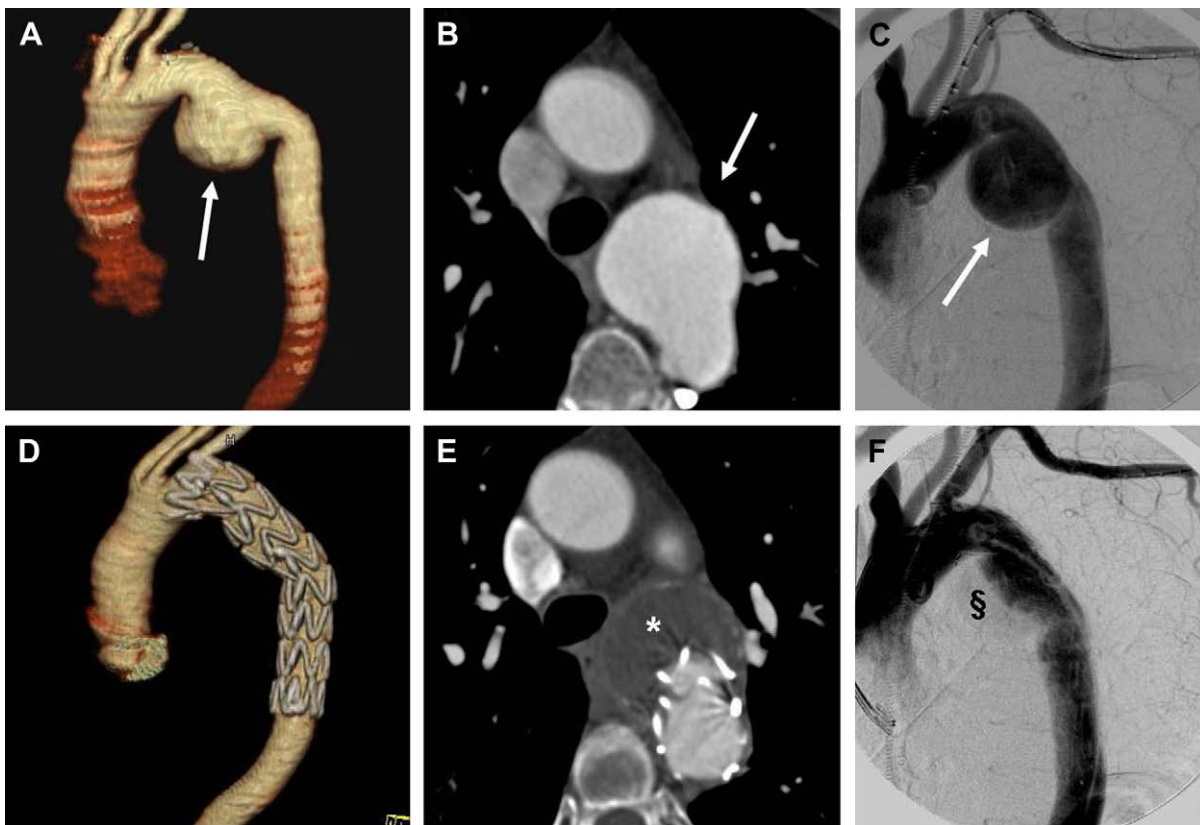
Multidetector CT images (A, B, D, E) and angiographic images (C, F) of a large chronic post-traumatic pseudo-aneurysm before (A–C) and after (D–F) endovascular treatment: the aneurysm (arrows) is partially thrombosed immediately after procedure (§) and fully sealed on CT scan at patient discharge (*).
